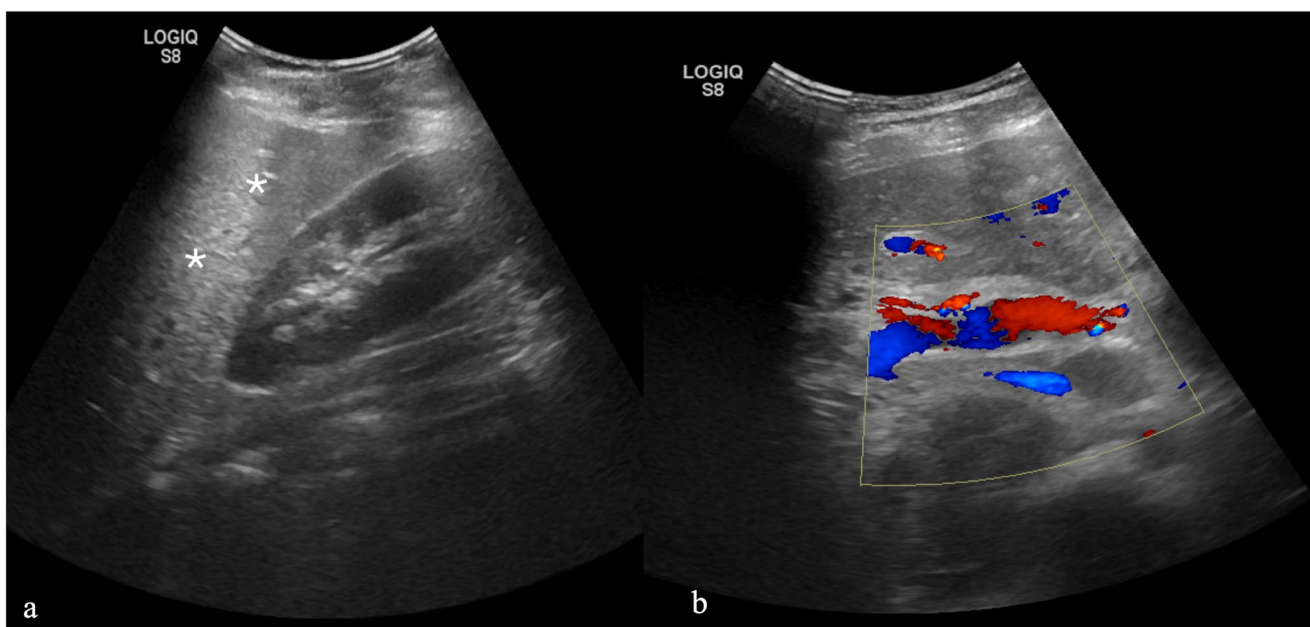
In a, ultrasound of a sixteen-year-old girl undergoing chemotherapy with methotrexate for acute lymphoblastic leukemia, showing the increased liver echogenicity (white asterisks) consistent with hepatic steatosis. In b, Color-Doppler showing the initial inversion of the flow in the portal vein which is suggestive of sinusoidal obstruction
